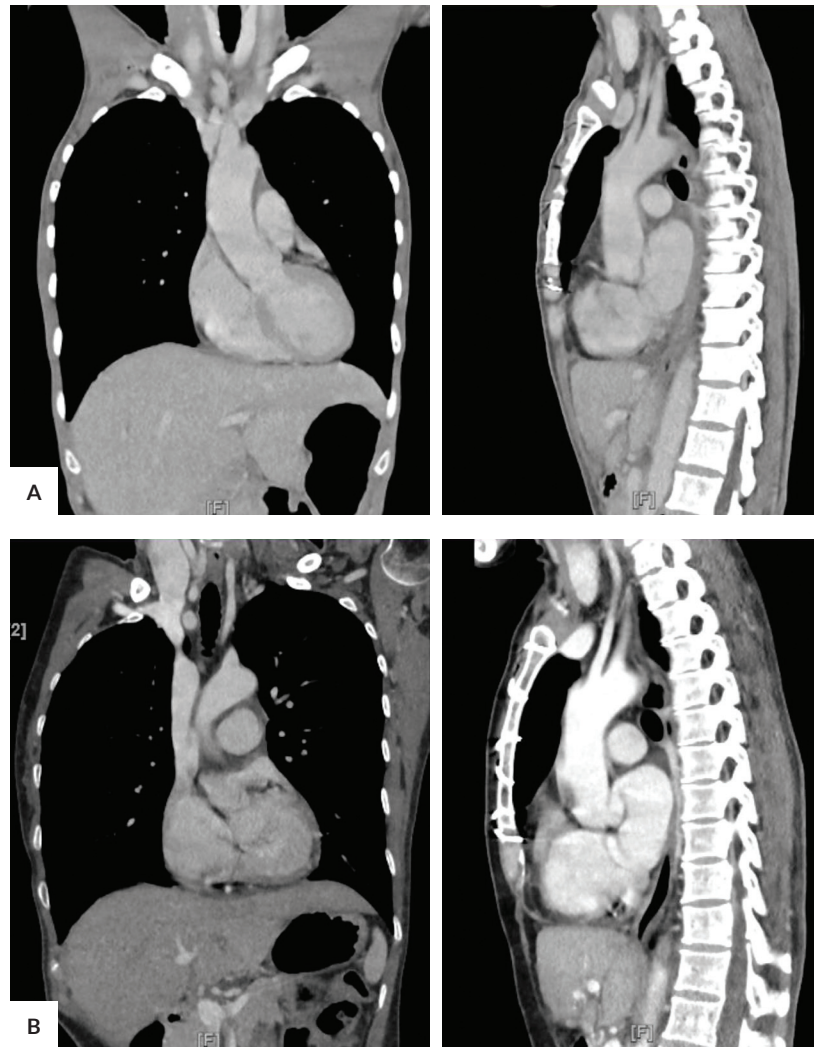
CT scan showing (A) Complete remission after four series of chemotherapy; (B) No recurrence after six months on follow-up.
